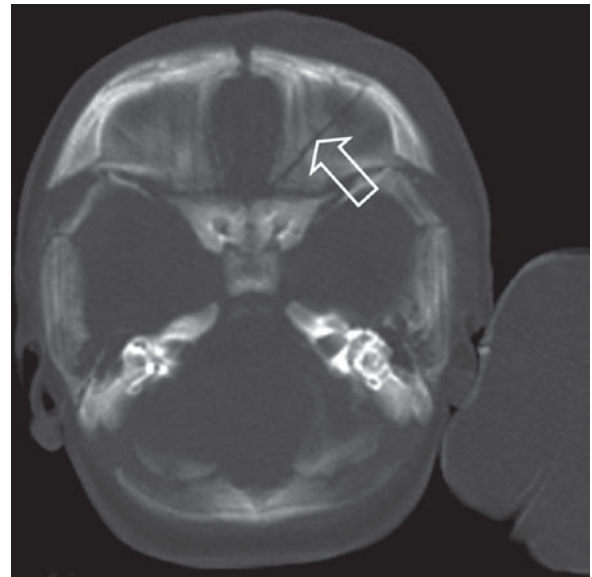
Three-month-old infant girl who sustained a severe neurological trauma and presented in coma at the emergency department. CT of the orbit showed a left basilar fracture (*open arrow*). Interrogation by the police revealed that the girl had been hit by a steel petanque ball
